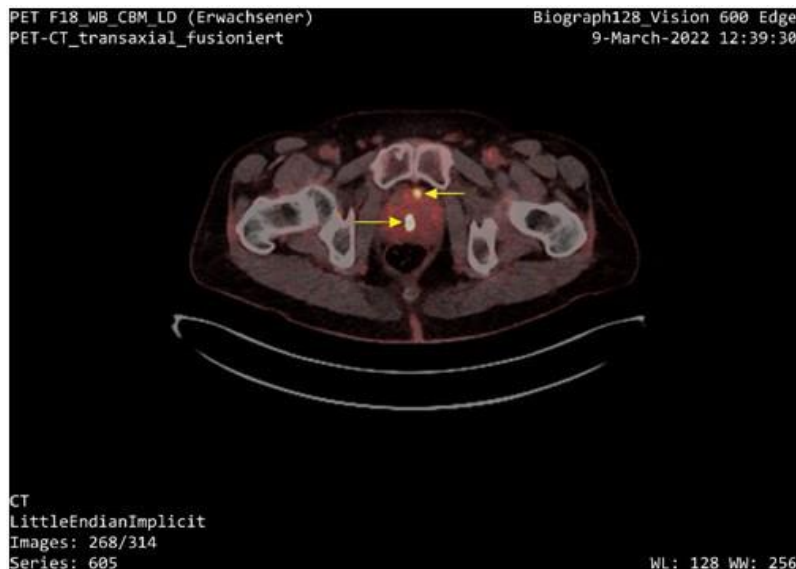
FDG PET/CT image of a patient with positive PanTum Test and a slightly elevated PSA level of 5.31 ng/ml. A diffuse FDG accumulation in the prostate is visible (marked with arrows).
